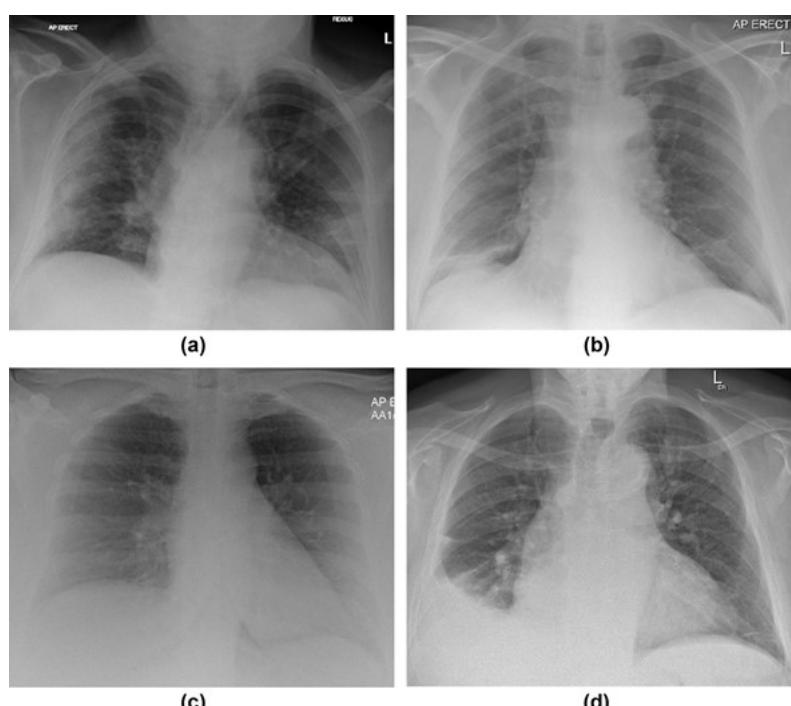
Examples of the COVID BSTI categories for plain films, in each case all radiologists agreed on the categorisation.
